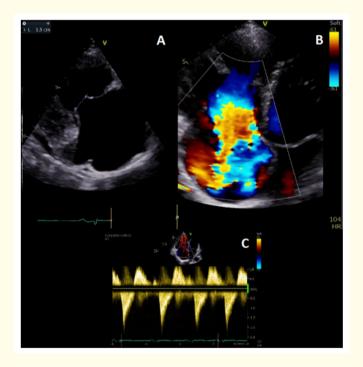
Transthoracic Echocardiography showing leaflets thickening and severe tricuspid regurgitation. (A) Parasternal long axis view of right chambers showing thickening of both anterior and septal tricuspid leaflets with a 13 mm coaptation defect. (B) Apical four chamber view with color flow doppler showing severe tricuspid regurgitation. (C) Continuous-wave Doppler profile of severe tricuspid regurgitation showing the characteristic dagger shaped spectrum with an early peak pressure and rapid decline.
